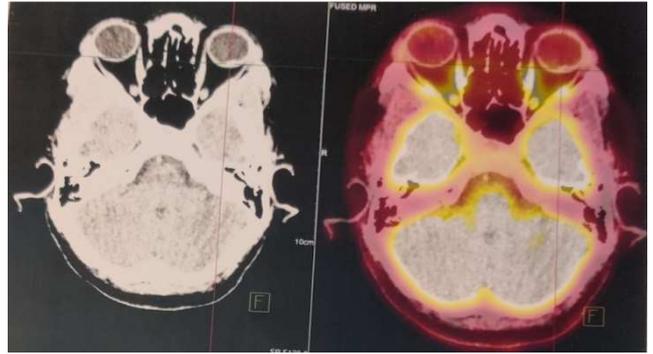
PET MRI (Case 1) shows radiopaque focal plaque like enhancing area in left globe posteriorly abutting the inner coats showing homogenous enhancement suggesting choroidal melanoma.
